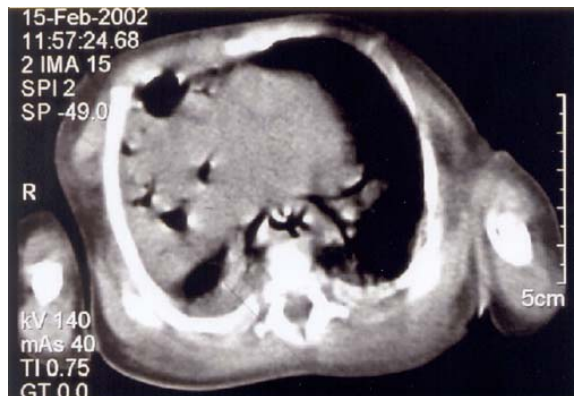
CT of the chest on the second day of admission demonstrating a solid mass with cystic areas of the right lung
